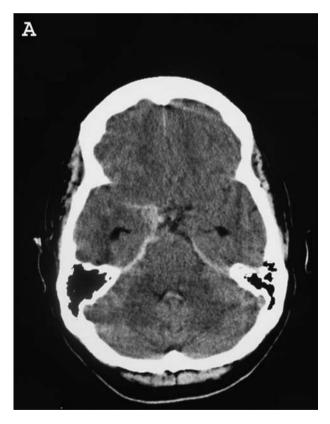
Head CT showing SAH in the deep cisternae (A) and blood in the posterior part of the left lateral ventricle (B). DSA showing a large saccular aneurysm (*arrow* in C) and DSA obtained after successful endovascular coiling, showing obliteration of the same aneurysm (*arrow* in D)
